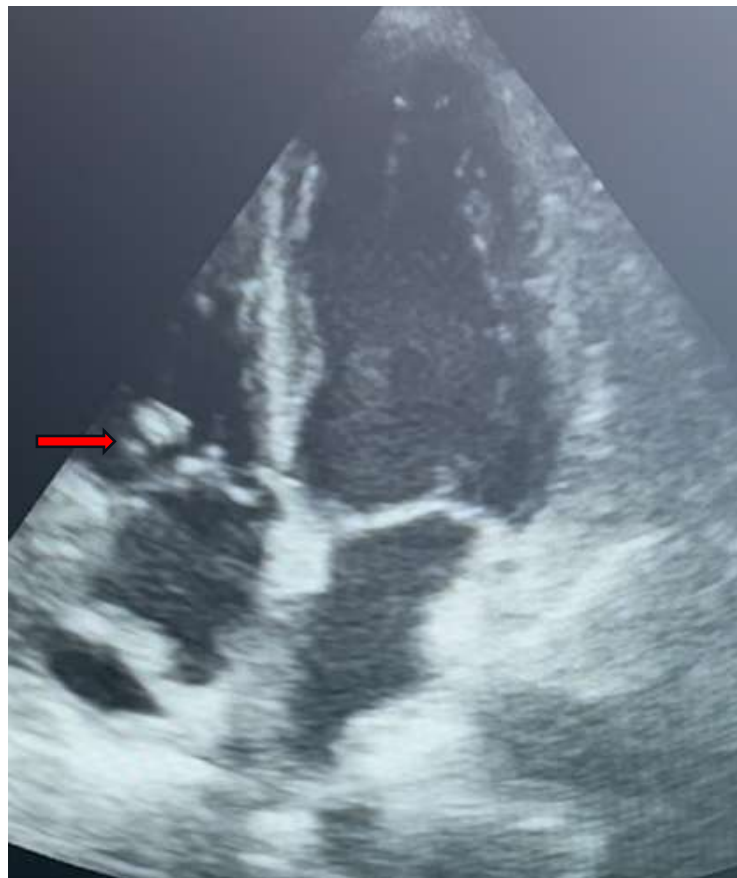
On this TTE in an apical four-cavity section, the red arrow indicates a big vegetation attached to the ventricular face of the septal cusp of the tricuspid valve. There was no significant tricuspid regurgitation associated.
